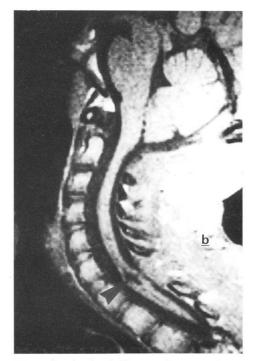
Preoperative T1-weighted MRI scans showing hydrosyringomyelia related with Chiari I malformation, b) 1 year after the PFD and SSS, no syringomyelic cavity was seen on T1-weighted MRI scans. The cervical spinal cord is largely deformed at the entry side of the syrinx catheter (arrow).
